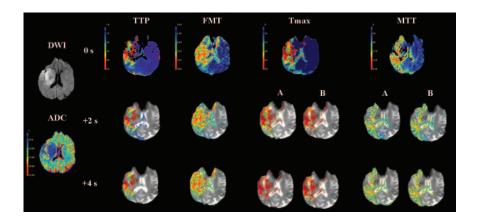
PWI maps demonstrating hypoperfused volumes in the right hemisphere decrease with application of +2s and +4s thresholds and DWI and ADC maps. The patient initially appears to have PWI-DWI mismatch, but this is not the case after thresholds are applied. Units are s (TTP) and one-tenth s (FMT, impulse residue TTP; Tmax and MTT). A indicates threshold relative to contralateral hemisphere; B, threshold relative to AIF.
